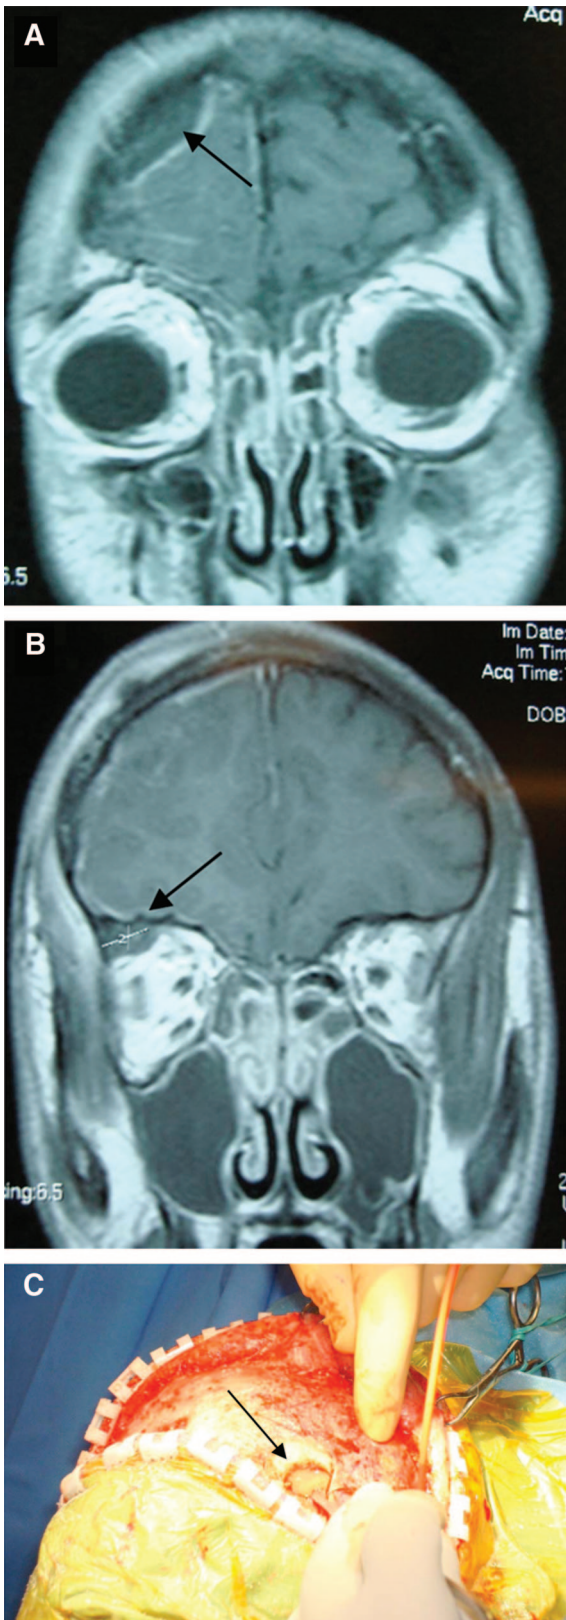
Case 1. Contrast-enhanced MRI demonstrates (A) a 30 mm × 11 mm epidural abscess (arrow) in the right frontal region and (B) a 11 mm × 16 mm abscess (arrow) in the right lateral extraconal orbit with complete opacification of the paranasal sinuses. (C), Intraoperative drainage of the epidural abscess (arrow).
